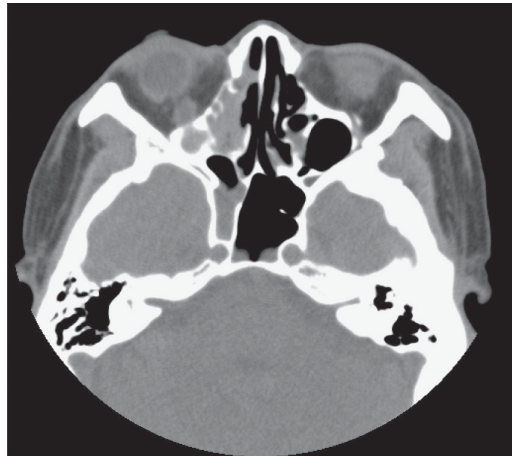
Sinus CT scan demonstrating maxillary fluid, soft tissue swelling into the orbit, and possible bony destruction.
